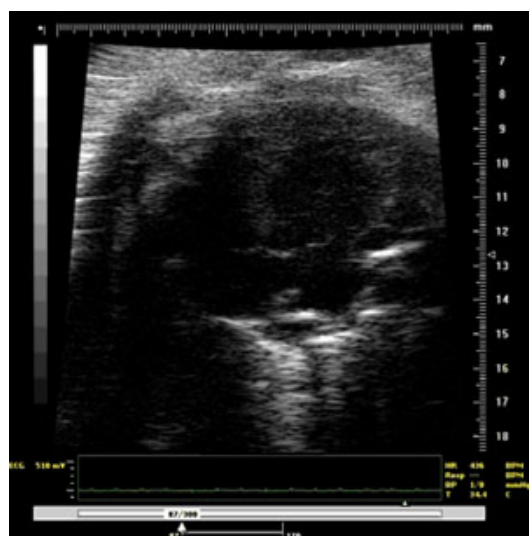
Parasternal short axis view B-Mode: endocardial border trace of the left ventricle at papillary level in a) diastole and b) systole.
